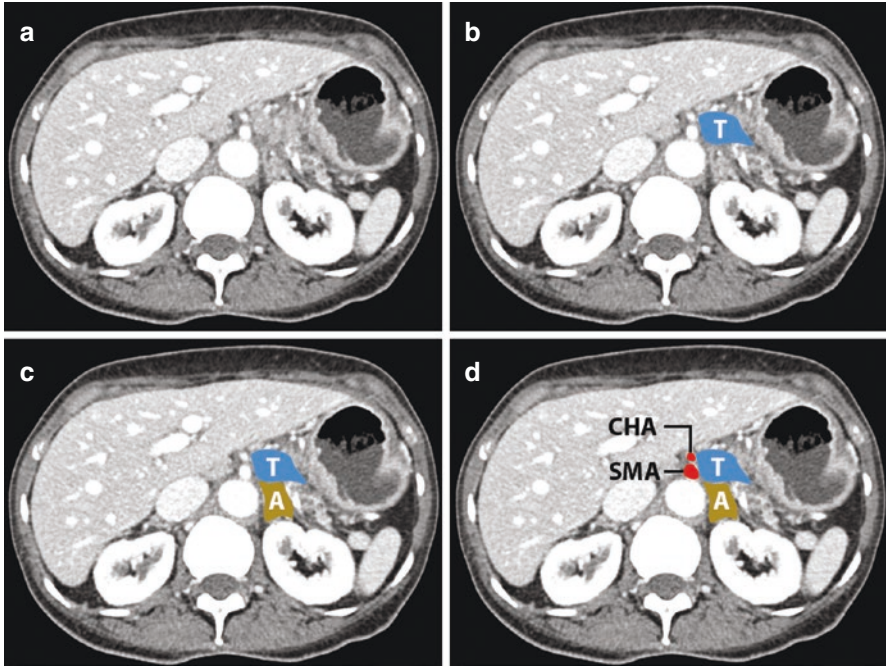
Four panel axial CT image with contrast of a patient with a pancreatic body ductal adenocarcinoma. (a) Unlabeled image. (b) Image showing the center of the tumor (T). (c) the left adrenal gland (A). (d) the common hepatic artery (CHA) and the superior mesenteric artery (SMA)
